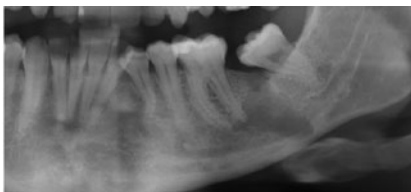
Orthopantomogram (OPG) showing a radiolucent lesion between the left mandibular first (36) and second molar (38), extending from the alveolar crest to the cortex of the lower border of the mandible
